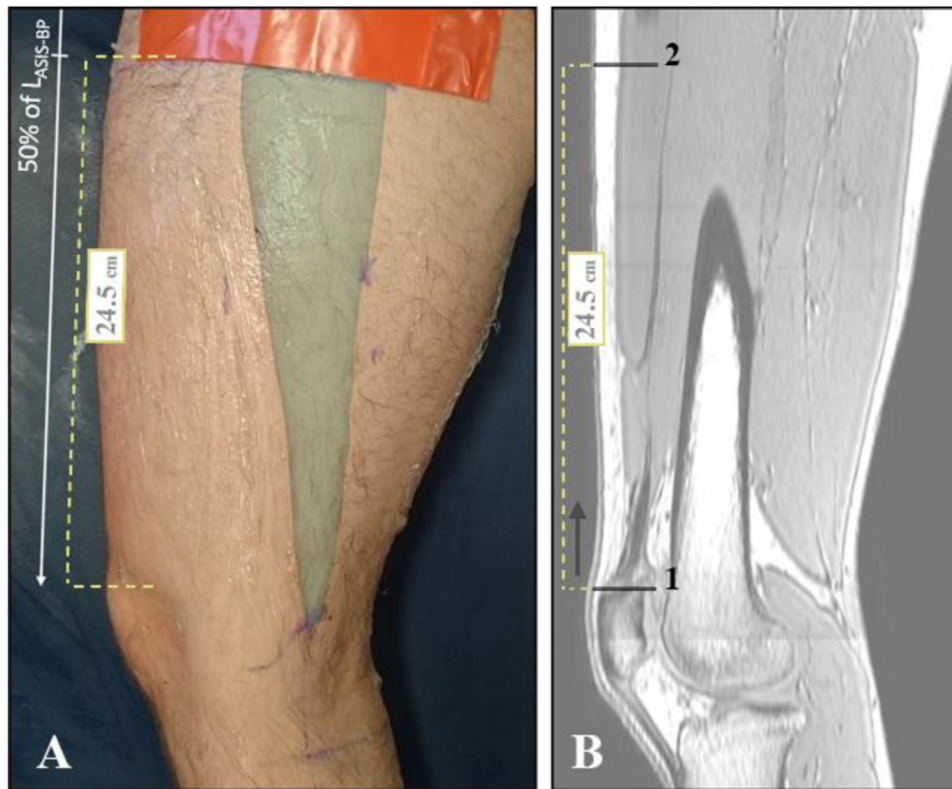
Anatomical landmark used to measure the muscle volume of the gracilis. The anatomical landmark was first determined during the 3-D ultrasound session (A) as 50% of the length between the anterior superior iliac spine and the base of the patella ($L_{ASIS-BP}$). It was transferred to the magnetic resonance imaging scans (B) by identifying (i) the base of the patella, and then by moving up the distance in a straight line to the location of the adhesive strip (ii) where the segmentation could then start proximally.
